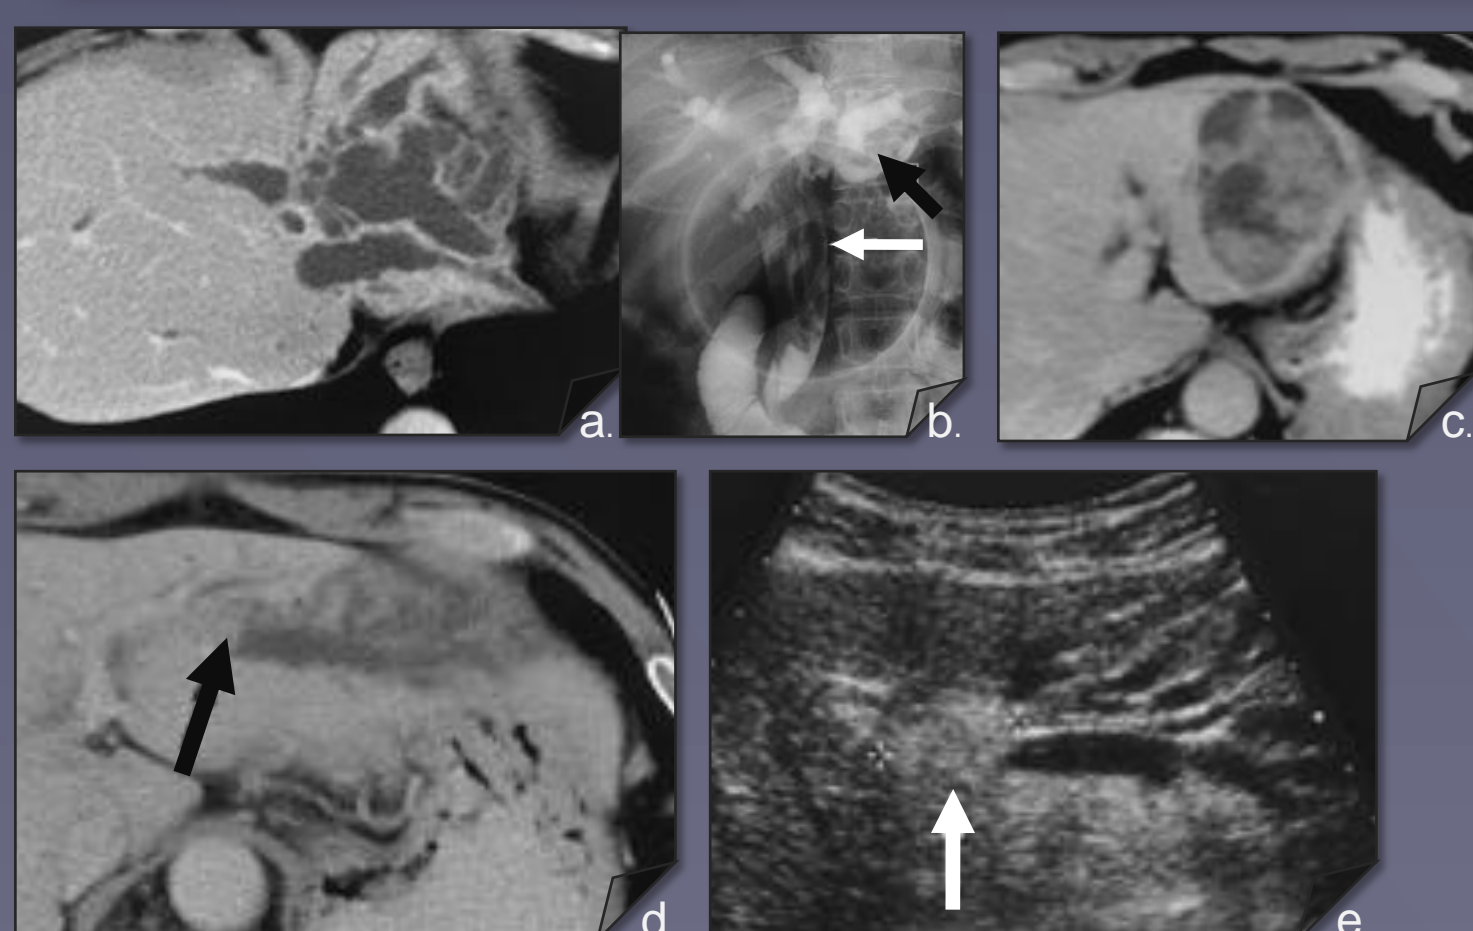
(a) Venous phase axial CT image shows severe dilatation of the left and right intrahepatic bile ducts and marked dilatation of the extrahepatic bile ducts but no tumor. Note the disproportionately greater dilatation of the left hepatic bile ducts. (b) ERCP image shows, once more, severe dilatation of the biliary tree, especially the left hepatic ducts and multiple cordlike filling defects (white arrow) that represent mucin in the extrahepatic bile ducts. Note also the oval filling defect (black arrow), which indicates the presence of a nodule in the lateral segmental bile duct of the left hepatic lobe. (c) Venous phase axial CT image show aneurysmal dilatation of the lateral segmental bile ducts of the left hepatic lobe containing multiple fungating masses. (d) Venous phase axial CT image and (e) axial US image show a nodular mass (black and white arrows) causing severe dilatation of the lateral segmental bile ducts of the left hepatic lobe.
